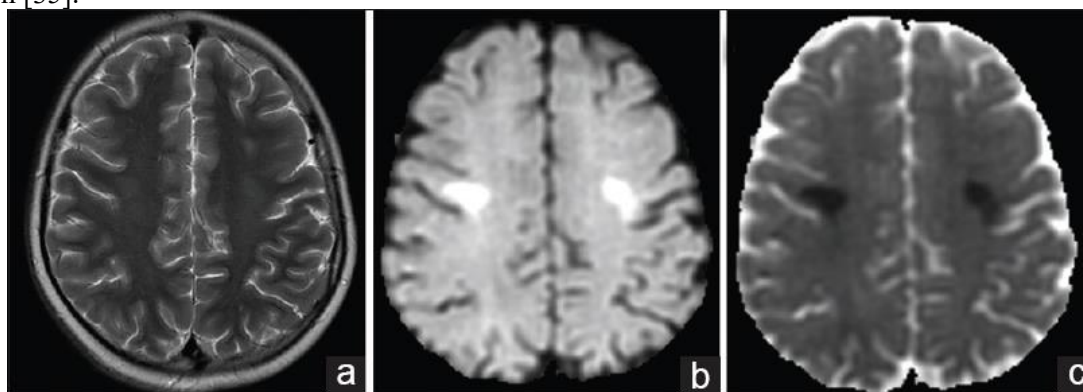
A 16-year-old boy with leukemia. Ten days after the 2nd high-dose methotrexate dose, the patient developed dysarthria and dysphagia. The patient had complete resolution of symptoms spontaneously within 24 hours. His computed tomography and magnetic
